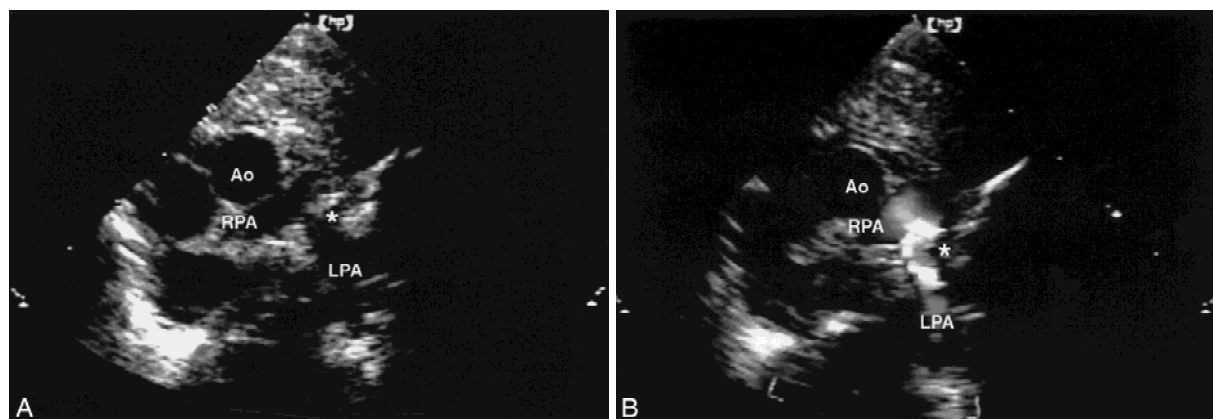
(A) Suprasternal coronal view demonstrates a tumor (*) in the proximal left pulmonary artery (LPA) at the bifurcation of the main pulmonary artery. (B) Suprasternal coronal view with color-flow Doppler demonstrates the aliasing at the takeoff of the LPA and obstructive nature of the tumor (*). Ao, aorta; RPA, right pulmonary artery.
